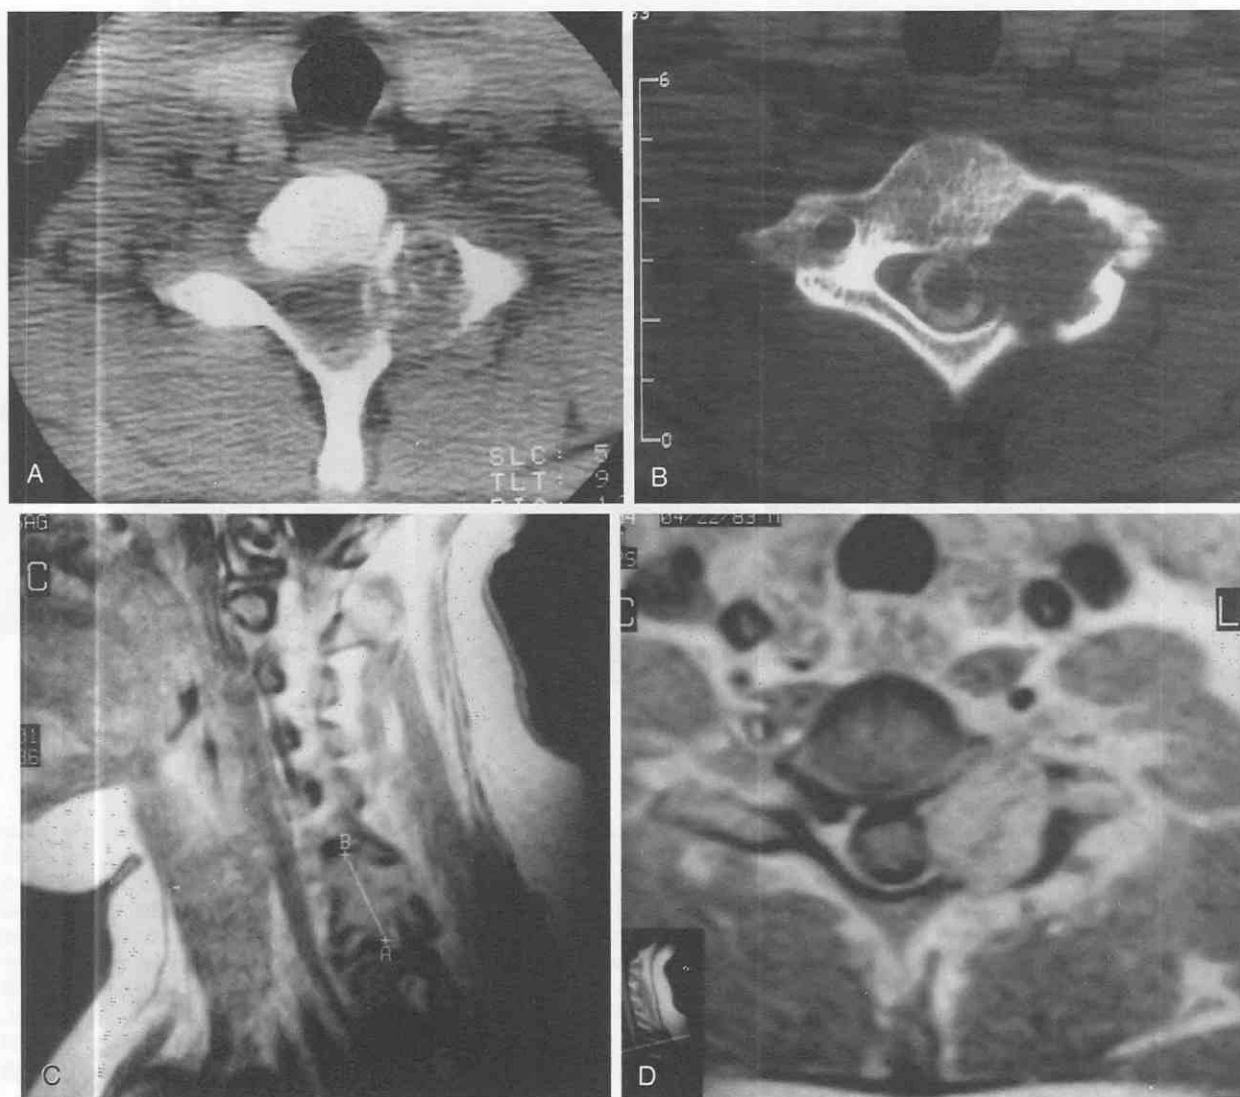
A, Axial CT image through C7 demonstrating an expansile osteoblastoma of the C7 facet. B, Axial CT image after myelogram through C7 showing the mass involving the vertebral artery foramen on the left. C, T1-weighted sagittal image after injection of contrast material with the enhancing mass involving the left C7 facet. D, T1-weighted axial image through the osteoblastoma involving the C7 facet and lamina.
